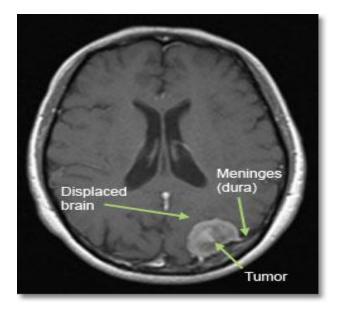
MRI image showing a typical meningioma tumor.⁶¹
